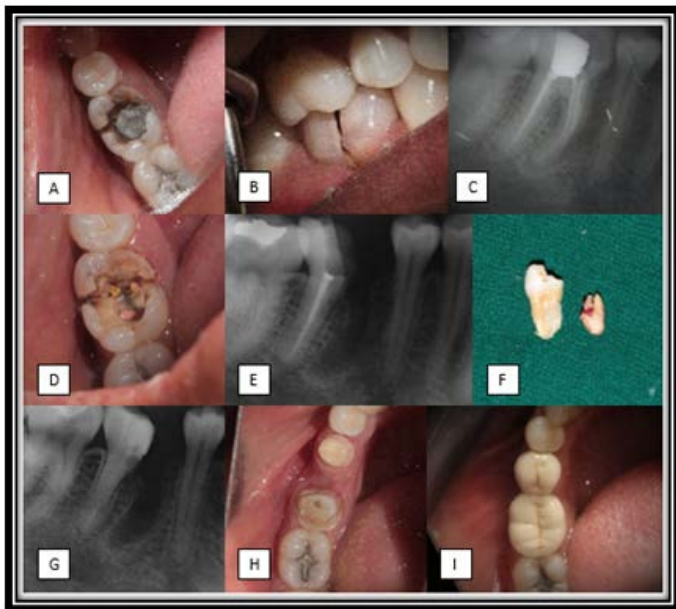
(A) Preoperative Photograph, (B) Fracture line running into furcation, (C)Preoperative radiograph, (D) Preoperative photograph after removal of restoration, (E) Immediate post Hemisection radiograph, (F) Hemisected mesial root, (G) Radiograph following fiber post placement, (H) Crowning cutting for fixed partial denture, (I) Occlusal view of fixed partial denture.
